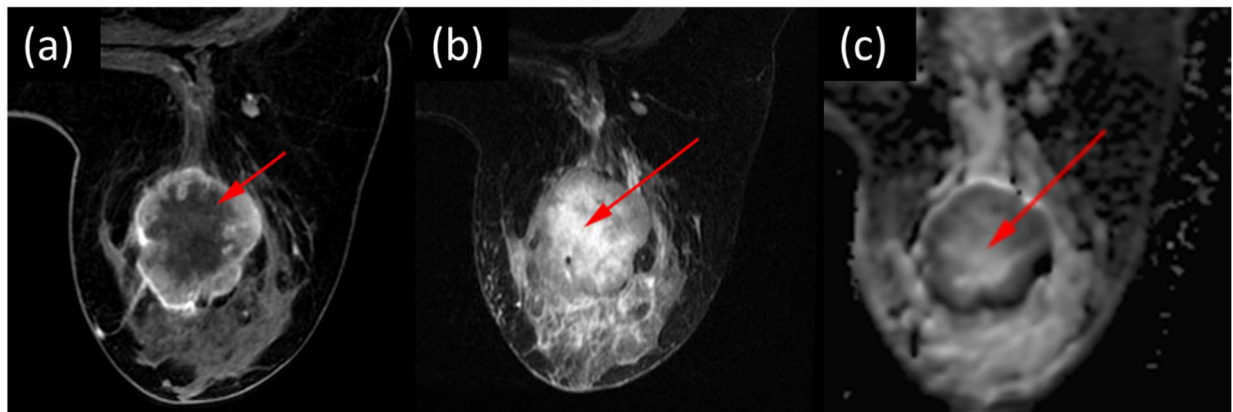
Necrosis in a 35-year-old woman with TNBC of the left breast. (a) Axial fat-suppressed early-phase dynamic contrast-enhanced image shows central non-enhancing area representing necrosis (arrow). (b) Axial fat-suppressed T2-weighted image shows necrosis as central area of high signal intensity (arrow). (c) Axial apparent diffusion coefficient map shows shine-through corresponding to central area of necrosis (arrow) seen on dynamic contrast-enhanced and T2-weighted imaging.
